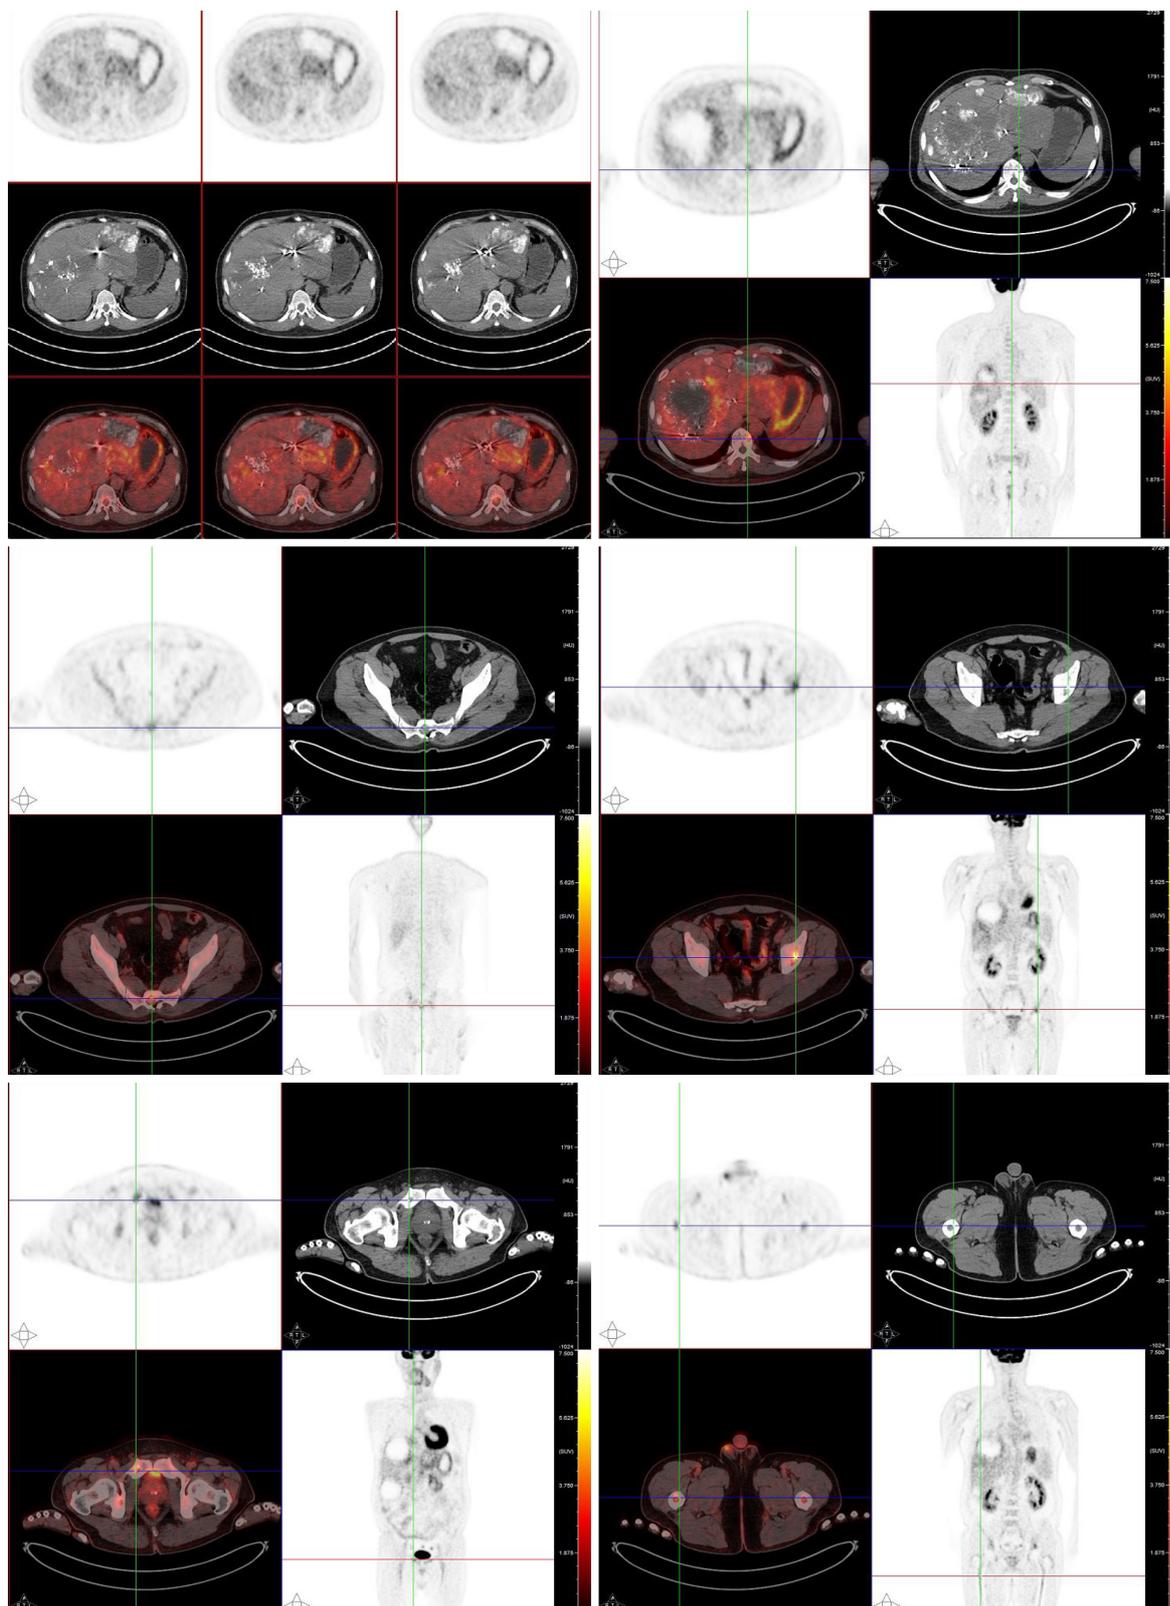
Systemic fluorine-18 fluorodeoxyglucose positron emission tomography/computed tomography scan. The positron emission tomography/computed tomography scan revealed an increased uptake of fluorodeoxyglucose in the liver and heterogeneous fluorodeoxyglucose uptake in multiple bones.
